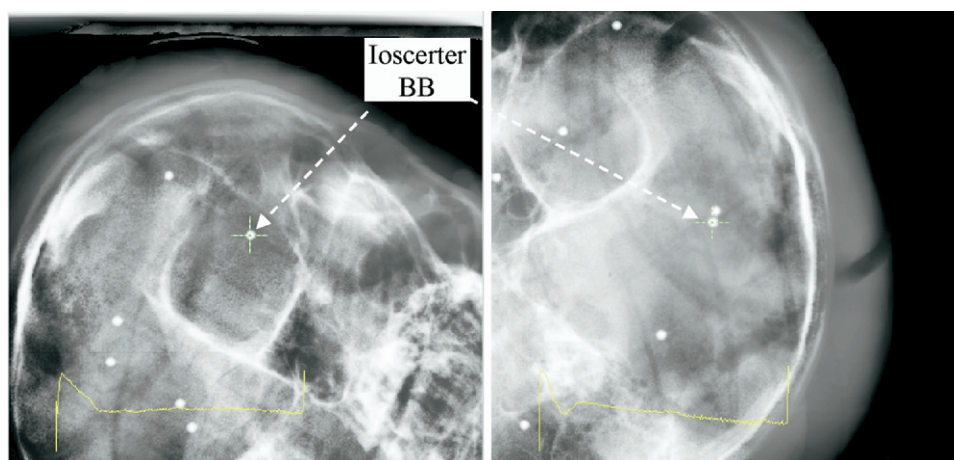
Two verification kV x-ray images for evaluating the localization accuracy, which is determined by measuring the distance between the isocenter of the x-ray system (represented by the cross) and the treatment isocenter (represented by the center of the BB). The treatment isocenter seems to be excellently coincided with the x-ray system's isocenter in this pair of images. Only some of the 8 BBs are shown in the images due to limited view size.
